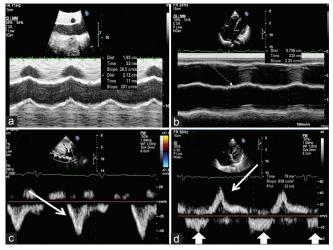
2D echocardiographic evaluation. (a) M-mode of inferior vena cava with no inspiratory collapse. (b) Tricuspid annular planar excursion of 7.5 mm. (c) Pulse Doppler of hepatic vein with maximum forward flow in early diastole (arrow). (d) Pulse Doppler across the tricuspid valve with maximum filling in early diastole (thin arrow) and low-pressure tricuspid regurgitation (thick arrows)
